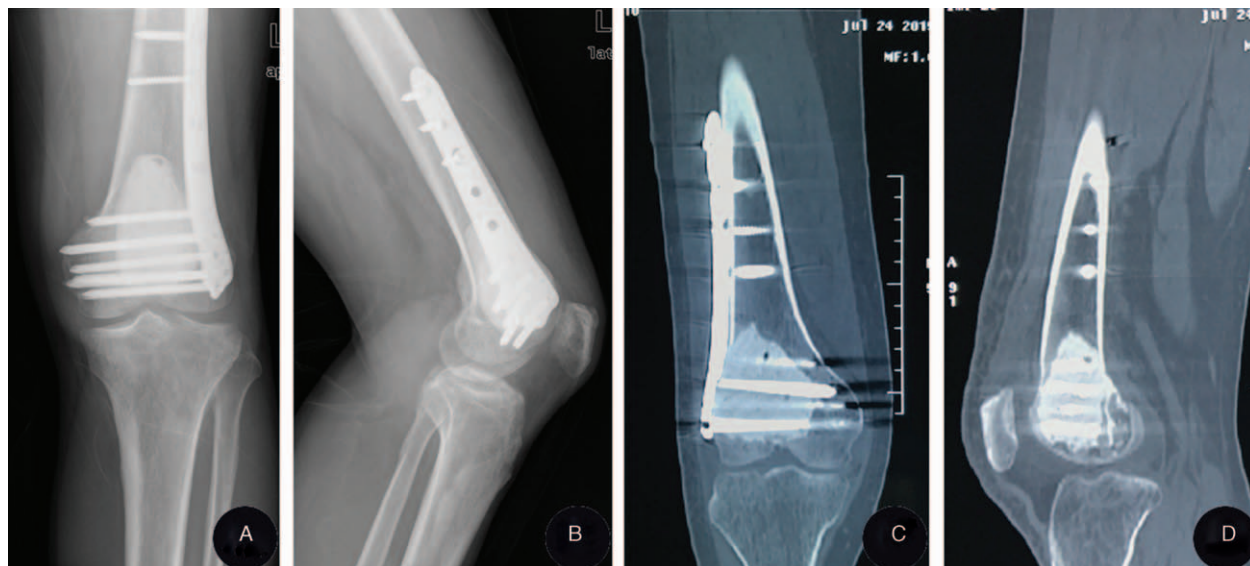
(A–D) 36-month follow-up X-ray and computed tomography scan show good remodeling of the subchondral bone graft without evidence of joint degeneration.
